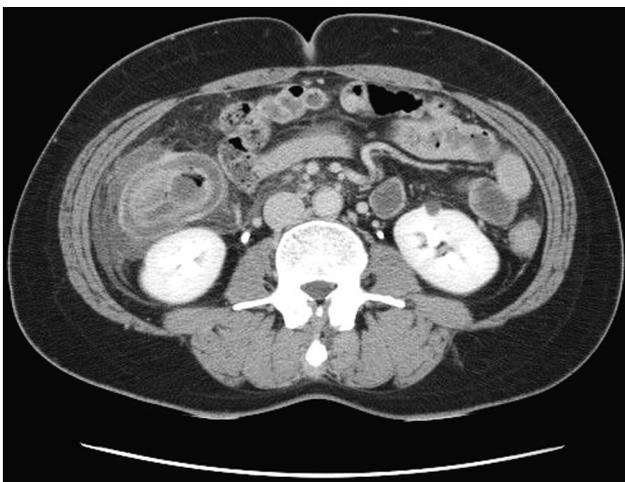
Abdominal CT showing a classic target lesion, suggesting either ileocolic or ileocecal intussusception
